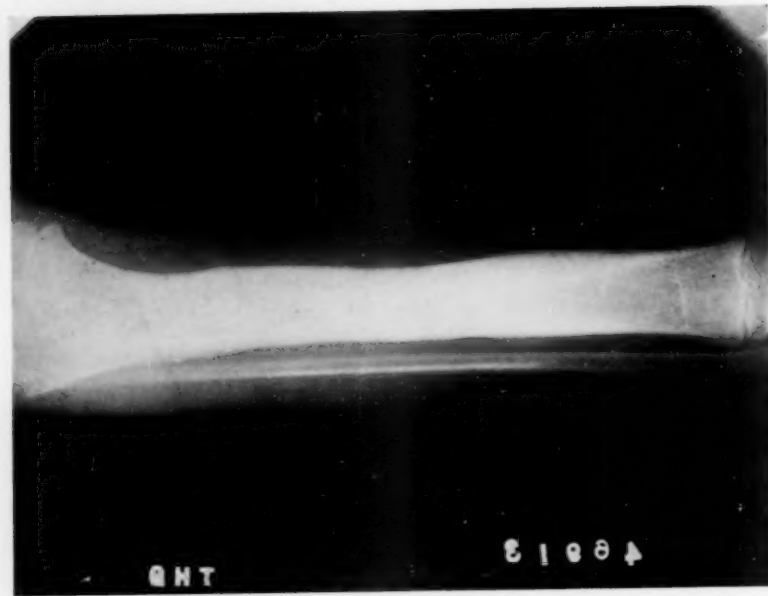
Clinical case No. 9. Operation June 22, 1919. X-ray November 24, 1919. No sinus. Patient apparently well.
